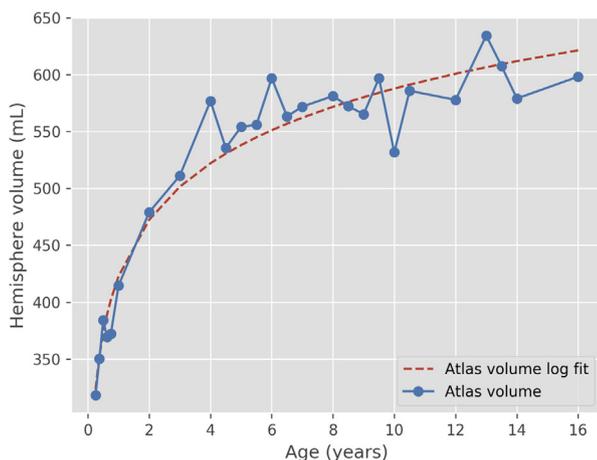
Hemispheric volume growth curve of healthy individuals. The data points were adapted from the Neurodevelopmental MRI Database maintained by Dr. John E. Richards at the University of South Carolina, with permission^{8,9} The logarithmic curve (dashed line) was fitted to the database and used as control in this study. The color version of this figure is available in the online edition.
